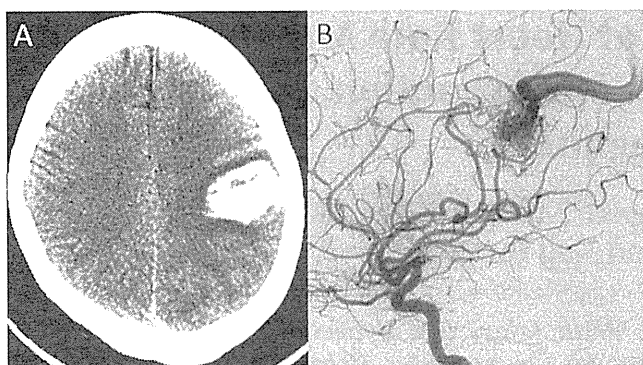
Case 1: A: Computed tomography scan showing a left parietal intraparenchymal hematoma. B: Digital subtraction angiogram showing a grade 2 left parietal arteriovenous malformation.
